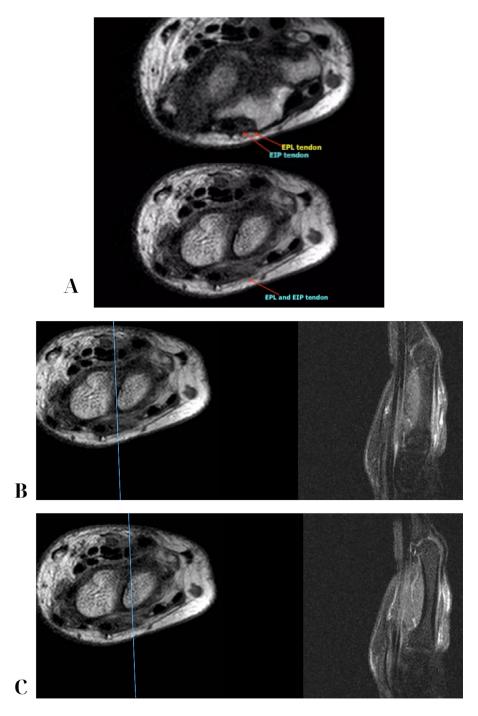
The MRIs at the level of Lister's tubercle in the right wrist reveal complete disruption of both the extensor pollicis longus (EPL) and extensor indicis proprius (EIP) tendons. (A) The T1W-TSE axial MRI images show the signal loss of EIP and EPL tendons; (B) The T1W-TSE axial and PDW Spair sagittal images show the signal loss of EIP; (C) The T1W-TSE axial and PDW Spair sagittal images show the signal loss of EPL.
